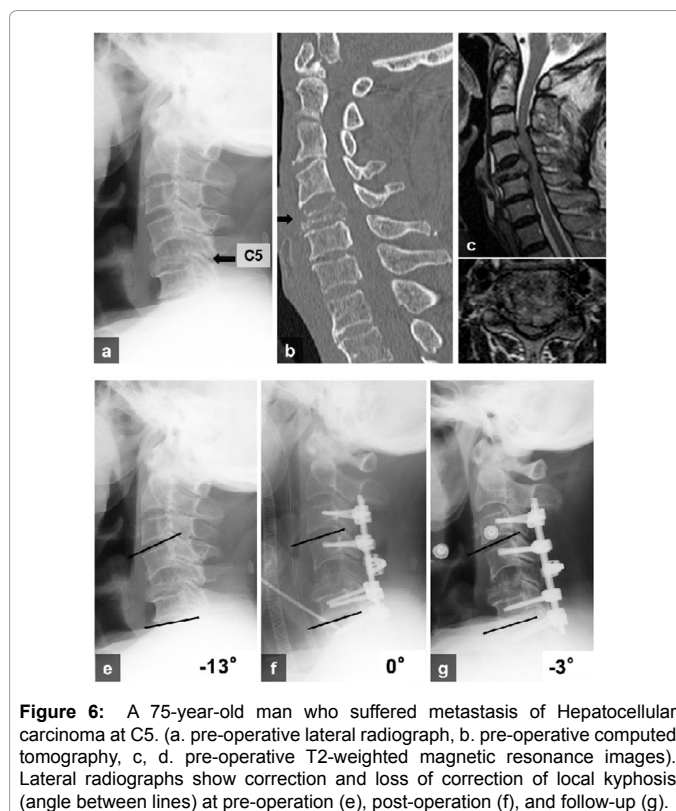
A 75-year-old man who suffered metastasis of Hepatocellular carcinoma at C5. (a. pre-operative lateral radiograph, b. pre-operative computed tomography, c, d. pre-operative T2-weighted magnetic resonance images). Lateral radiographs show correction and loss of correction of local kyphosis (angle between lines) at pre-operation (e), post-operation (f), and follow-up (g).
